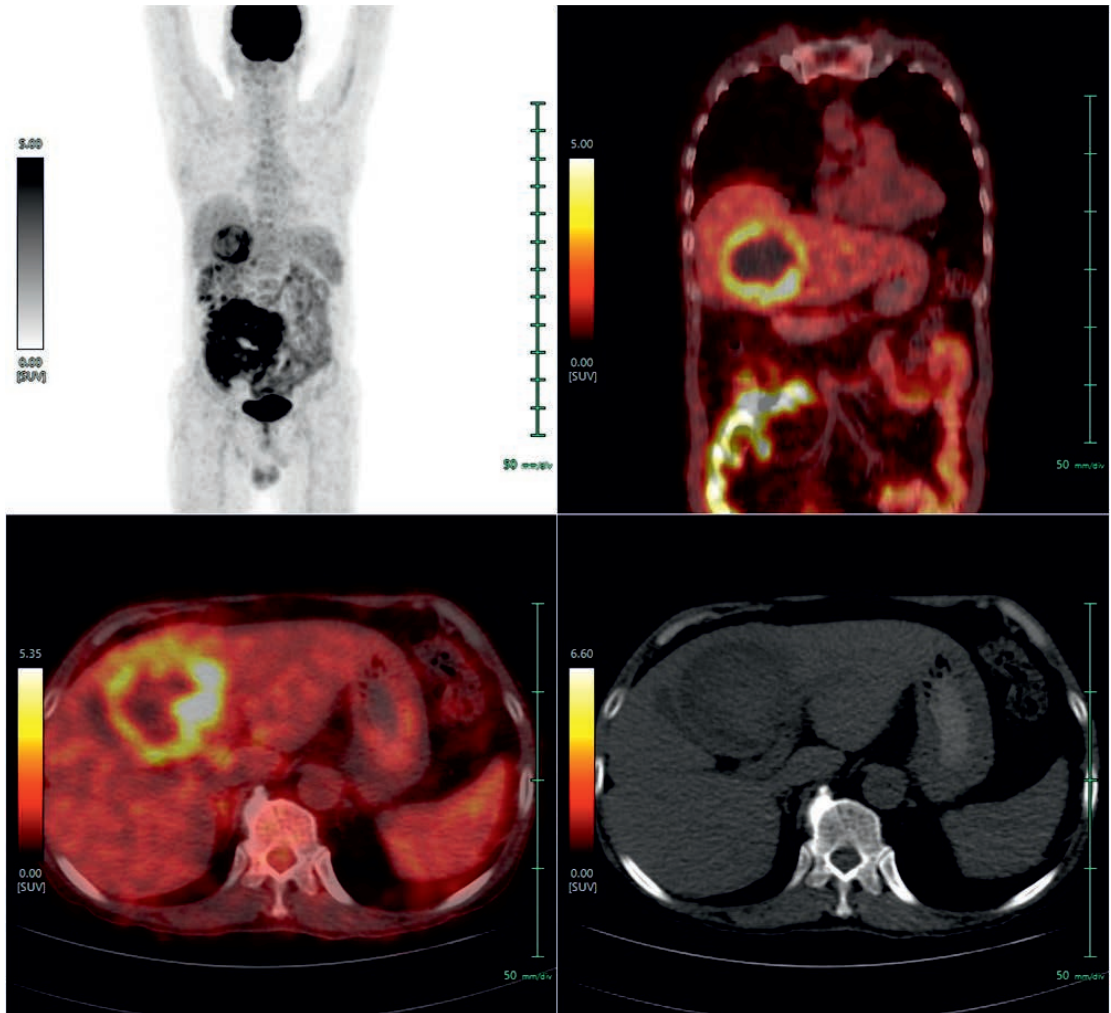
^{18}F -FDG-PET/CT FOR INFECTION IMAGING. A 60-year-old male patient, presented with Pyrexia of Unknown Origin (PUO); CRP: 122.7mg/dl; normal d dimer; sputum AFB & C/S negative; malaria negative; Patient was on antibiotics. The ^{18}F -FDG-PET/ CT scan demonstrated well defined, peripherally hypointense and centrally iso-intense liver lesion in segment IVA with peripheral FDG avidity, associated with central photopenia, the clinical and scan findings were favorable for liver abscess.
